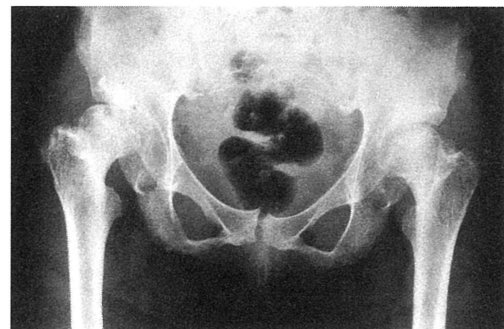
Pre-operative radiograph at 13 years of age.
